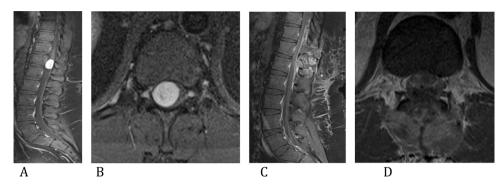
Pre- (A, B) and postoperative (C, D) MRI of a patient with SS localized at Th12, contrast-enhanced sagittal and axial T1 sequence.
